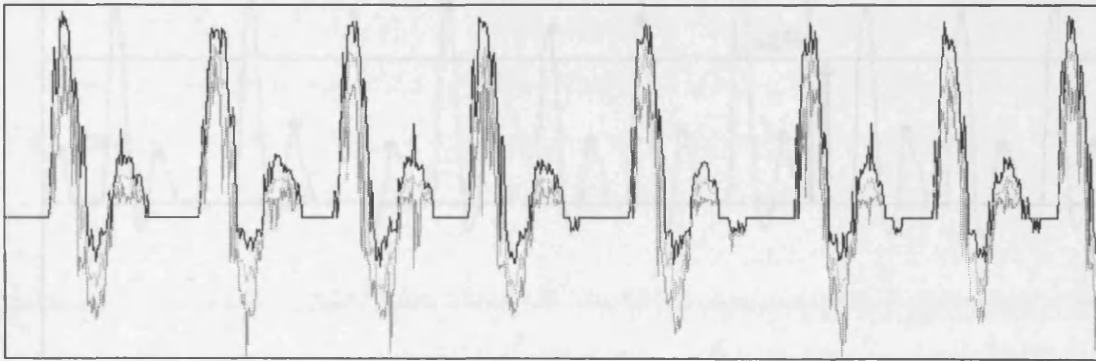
Raw f_{min} , f_{mean} and f_{max} frequency envelopes extracted from a sonogram of the femoral artery.
